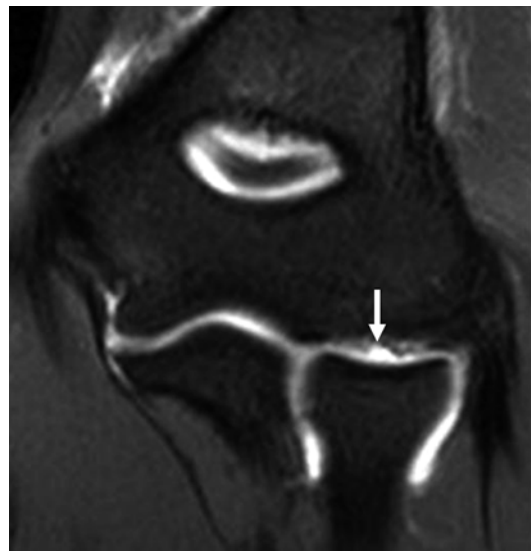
FS PD TSE coronal MR image demonstrating a partial tear of the MCL
